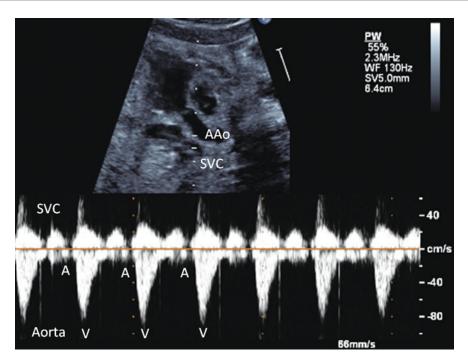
Normal pulsed Doppler tracing obtained using the SVC/Ao method. The sample volume is placed to include both the SVC and ascending aorta flows. Aortic ejection is seen below the *baseline*, while antegrade venous flow in the SVC is demonstrated above the baseline. Atrial contraction in the SVC is
